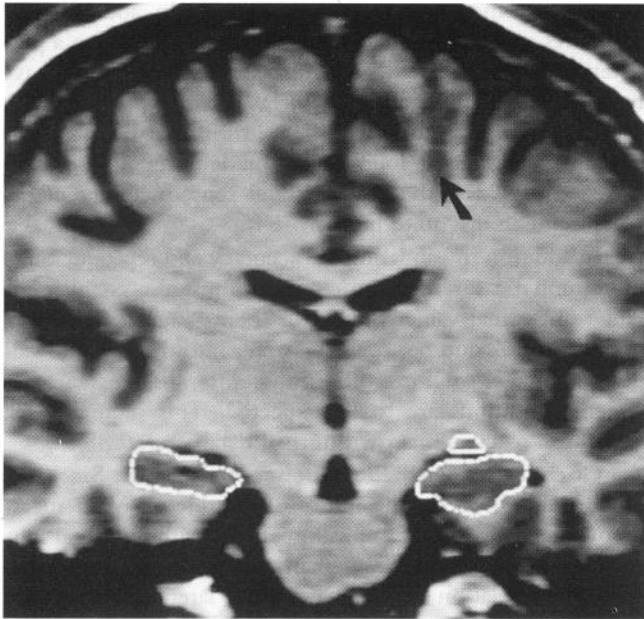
Coronal MRI scan showing an area of left frontal heterotopia (arrow) and normal and symmetric hippocampal volumes (outlined bilaterally). The patient had simple partial and complex partial seizures beginning in the left frontal lobe.
